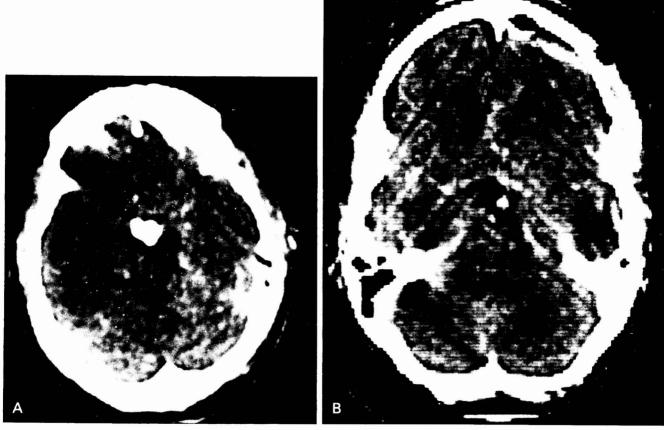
Case 4. A, enhanced CT scan after partial removal of the tumor and before the second operation. B, enhanced CT scan after removal of persistent tumor through the lamina terminalis at a second operation.
